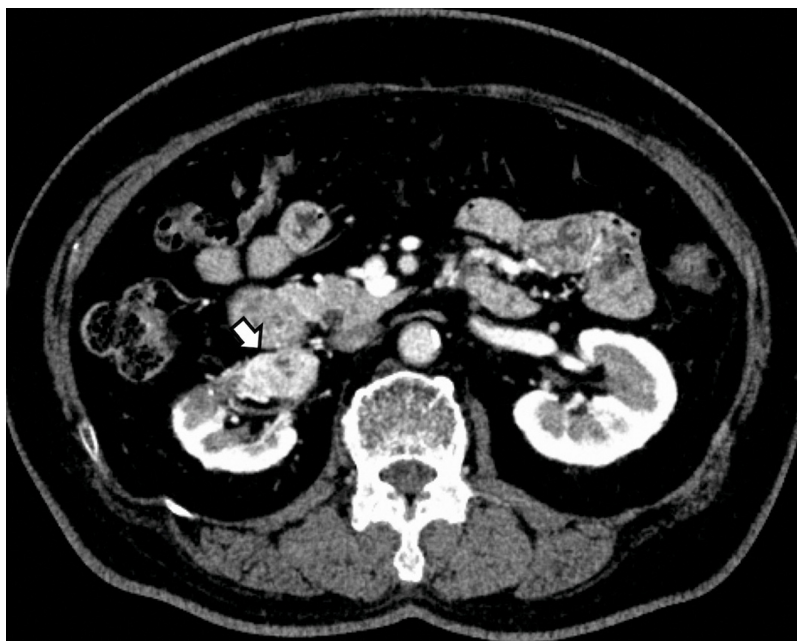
Computed tomography (CT) image of local recurrence in the right kidney. The 4-year follow-up CT after right salpingo-oophorectomy is shown. A mass with heterogeneous strong enhancement is seen in the right kidney in the cortico-medullary phase.
